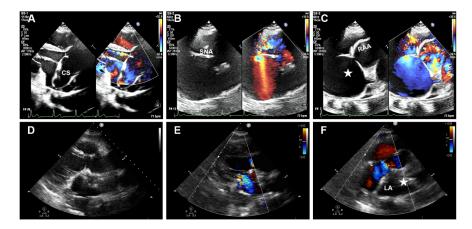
Pre- and postoperative TTE images. (A) Pre-TTE parasternal long-axis view reveals dilated left coronary sinus (CS), (B) Color Doppler imaging with systolic aliased flow in the sinus node artery (SNA). (C) Apical four-chamber view shows a 7.1×7.4 cm giant aneurysm (white star) fistula into the right atrial appendage (RAA). (D-F) Post-TTE shows a hypoechogenic mass of collapsed aneurysm (white star) in the posterior of the left atrium (LA).
